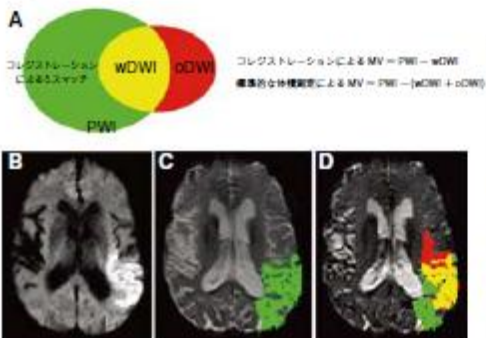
A: 灌流強調画像 (PWI) と拡散強調画像 (DWI) のコレジストレーションにより、DWI 病変は、PWI 病変内の DWI (wDWI, 黄色部分) と PWI 病変外の DWI (oDWI, 赤色部分) の 2 領域に分類できる。標準的な体積測定では、ミスマッチ体積 (MV) = PWI - (wDWI + oDWI) として計算されるが、コレジストレーションによる測定では、MV (緑色部分) = PWI - wDWI と定義される。脳卒中発症から 325 分後にベースラインの MRI を実施した 82 歳の女性では、ベースラインの DWI 病変の体積は 65.3 mL (B)、PWI 病変の体積は 68.8 mL (C、緑色の部分は Tmax が 2 秒以上の異常領域を示す) であった。EPITHET の体積測定方法では、ミスマッチなし (3.5 mL) と判定されたが、コレジストレーションによる測定 (D) では、ミスマッチあり (26.2 mL) と判定された (黄色部分は wDWI、赤色部分は oDWI、緑色部分はコレジストレーションによるミスマッチ領域)。
